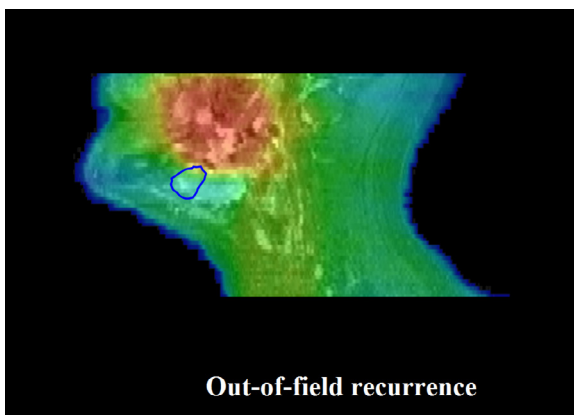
MR image of a patient with an out-of-field recurrence. The image is constructed similar to figure 2 but here the entire volume of recurrence was positioned outside the high dose area indicating an out-of-field recurrence.
